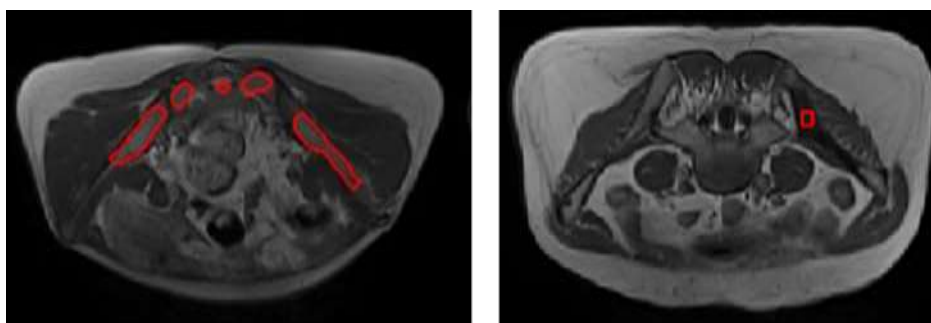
a-left) Image T1-weighted of bone marrow of the pelvic region of a non-metastasis patient, b-right) Image T1-weighted of an individual with breast cancer with bone marrow metastasis in pelvic region
